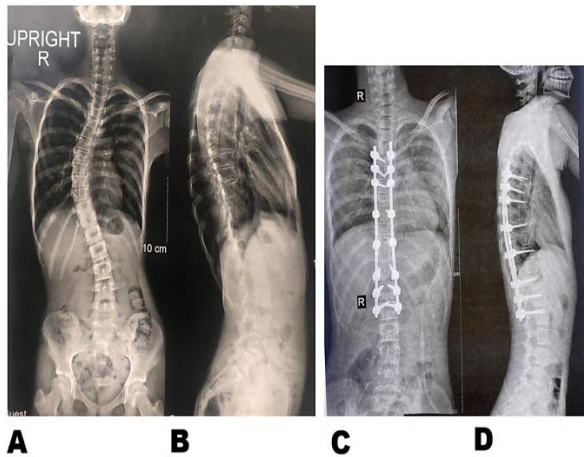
An 11-year-old girl undergoing T4-L5 posterior spinal fusion; A, B preoperative standing full length posteroanterior and lateral radiographs; C, D after deformity correction and instrumentation
